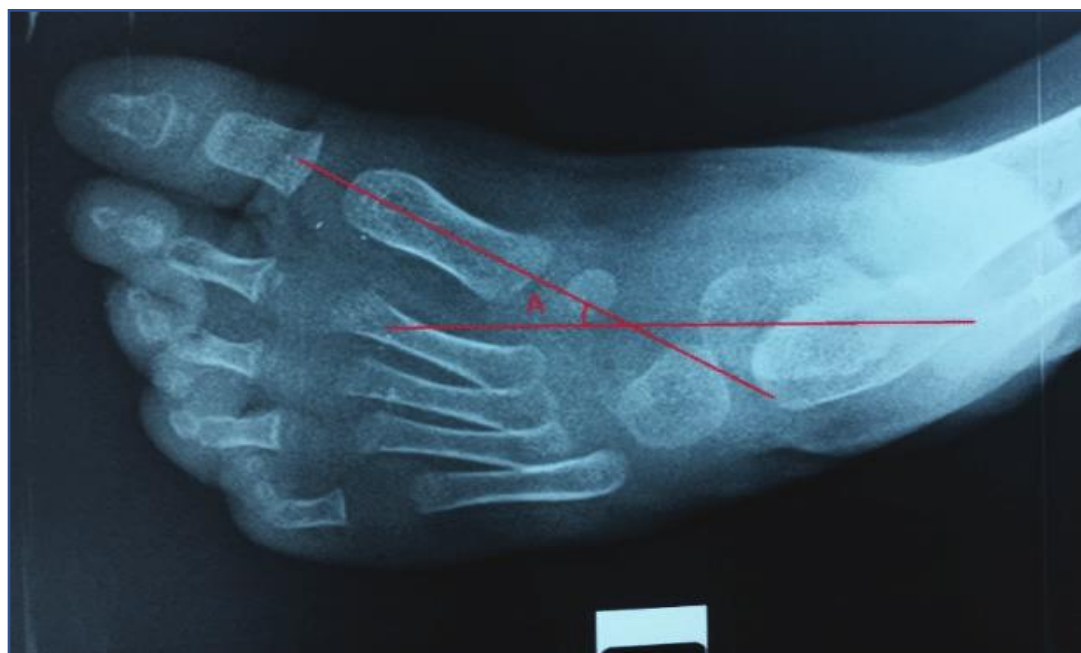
Left foot DP X-ray shows talo-1st metatarsal angle in a child with equinovarus deformity (4).
